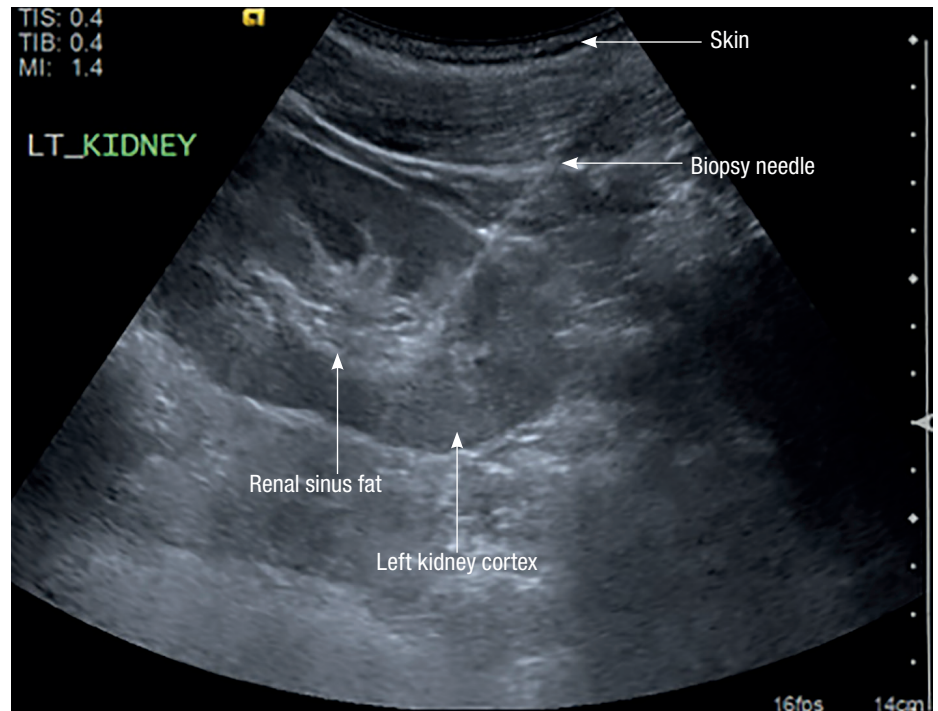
Ultrasound image showing the deployed biopsy needle within the cortex.
